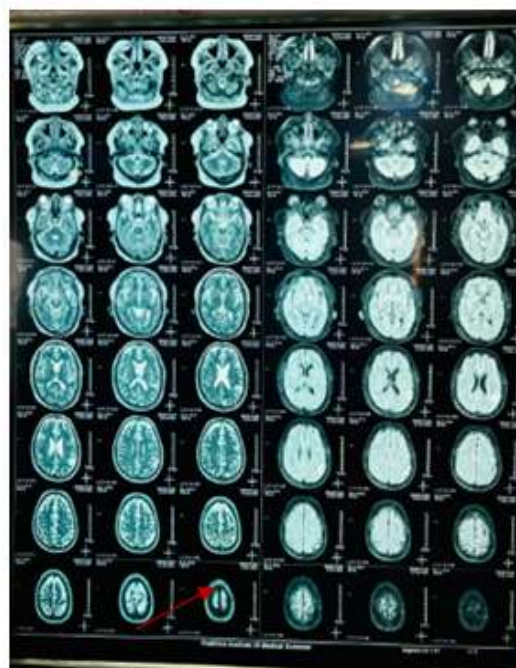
MRI scan of the brain demonstrating the clinical findings .
